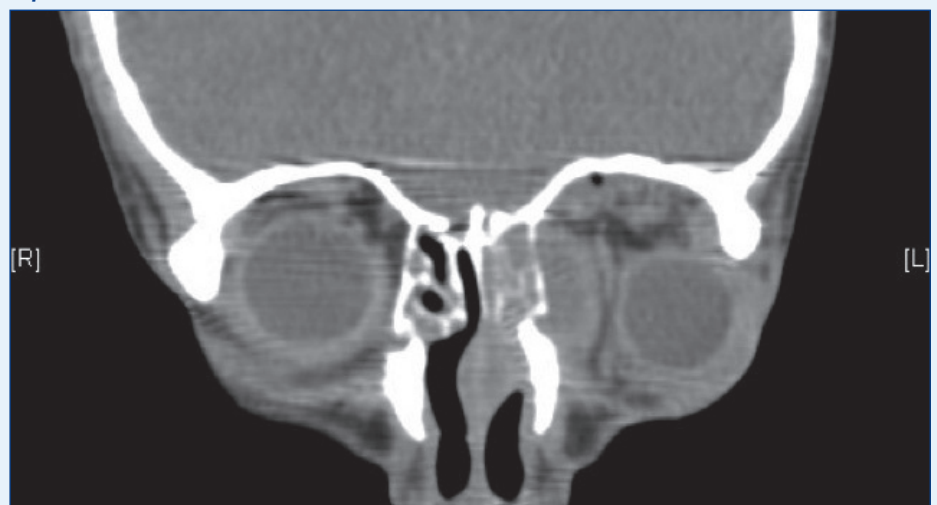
Coronal computed tomography scan of the same patient. Note left eye medial rectus and globe displacement.
